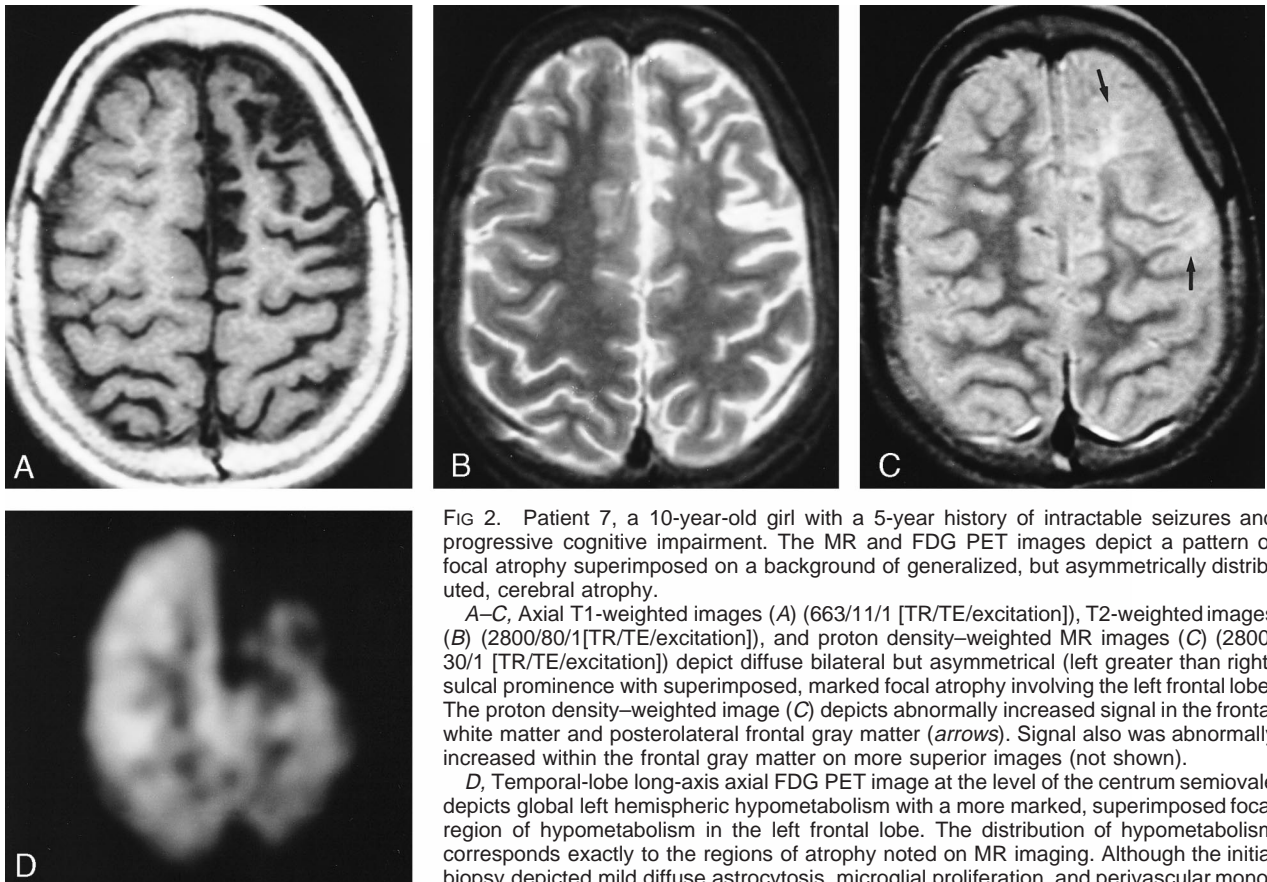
Patient 7, a 10-year-old girl with a 5-year history of intractable seizures and progressive cognitive impairment. The MR and FDG PET images depict a pattern of focal atrophy superimposed on a background of generalized, but asymmetrically distributed, cerebral atrophy.
